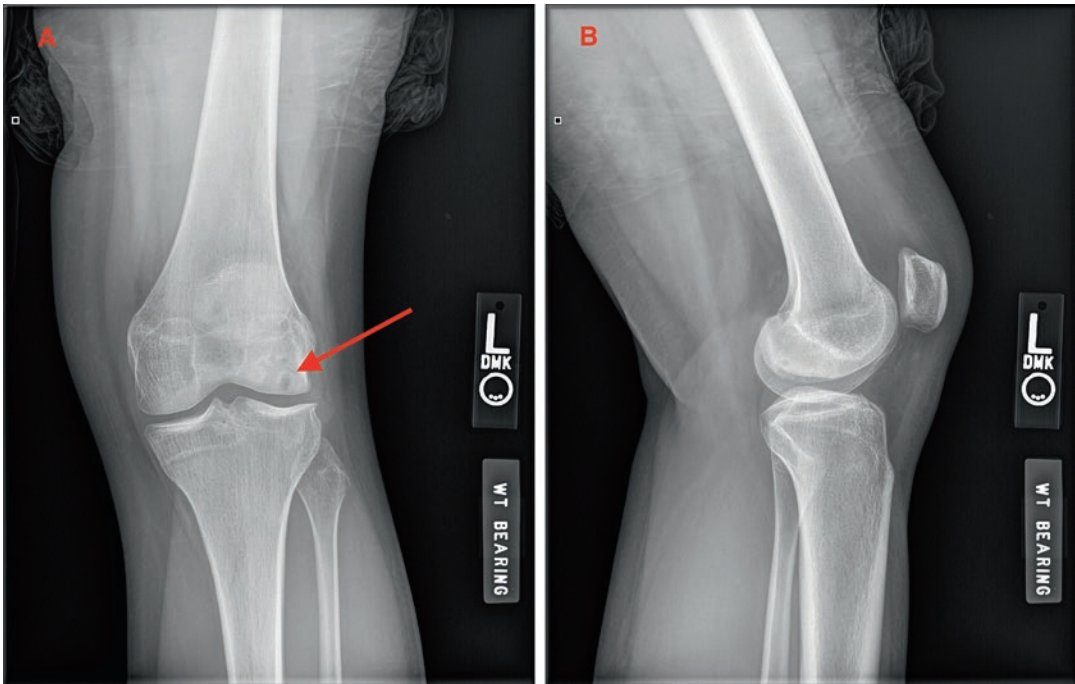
(a) Anterior-posterior radiograph of the left knee of a 15-year-old male demonstrating an osteochondral dissecans lesion of the lateral femoral condyle. (b)
